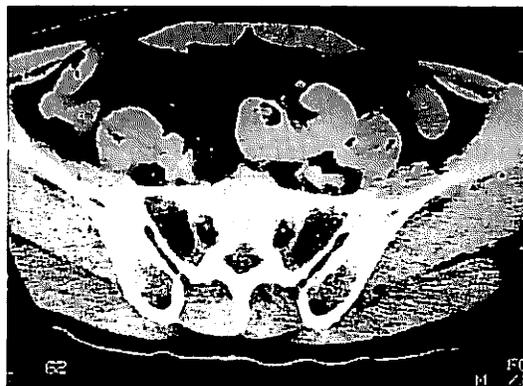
Computed tomography after intravenous pyelography shows the ectopic left kidney
